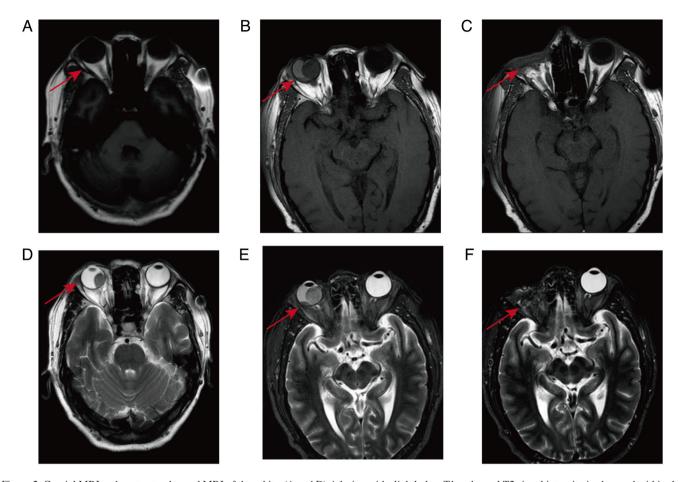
Cranial MRI and contrast-enhanced MRI of the orbits. (A and D) A lesion with slightly low T1 and equal T2 signal intensity is observed within the right eyeball. It has a clear boundary and dimensions of ~16x11 mm. After contrast administration, the lesion shows significant enhancement (Red arrow). (B and E) A lesion with slightly low T1 and equal T2 signal intensity is observed within the right eyeball, with a well-defined boundary and dimensions of ~14x5 mm. Post-contrast enhancement revealed a mildly uneven intensification of the lesion. Additionally, a cystic lesion with slightly high T1 and slightly high T2 signal intensity is visible on the lateral margin. Post-contrast enhancement shows high signal intensity, with dimensions of ~15x7 mm (Red arrow). (C and F) Absence of the right eyeball (Red arrow). MRI, magnetic resonance imaging.
